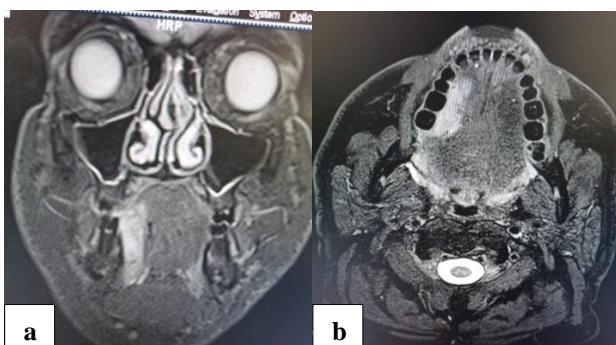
(a) Coronal section of magnetic resonance imaging 1×3.5 cm hypointense lesion not crossing midline involving right lateral border of tongue anterior two thirds; and (b) axial section of magnetic resonance imaging 1×3.5 cm hypointense lesion not crossing midline involving right lateral border of tongue anterior two thirds.
